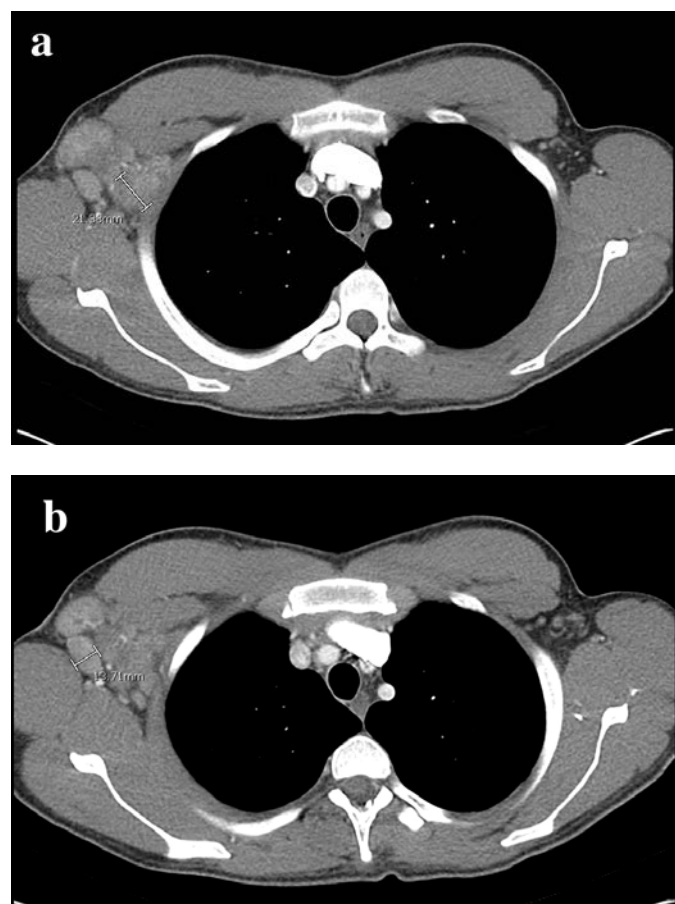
CT thorax showed unilateral enlarged (a) 2.1cm, and (b) 1.3cm right axillary lymph nodes.
